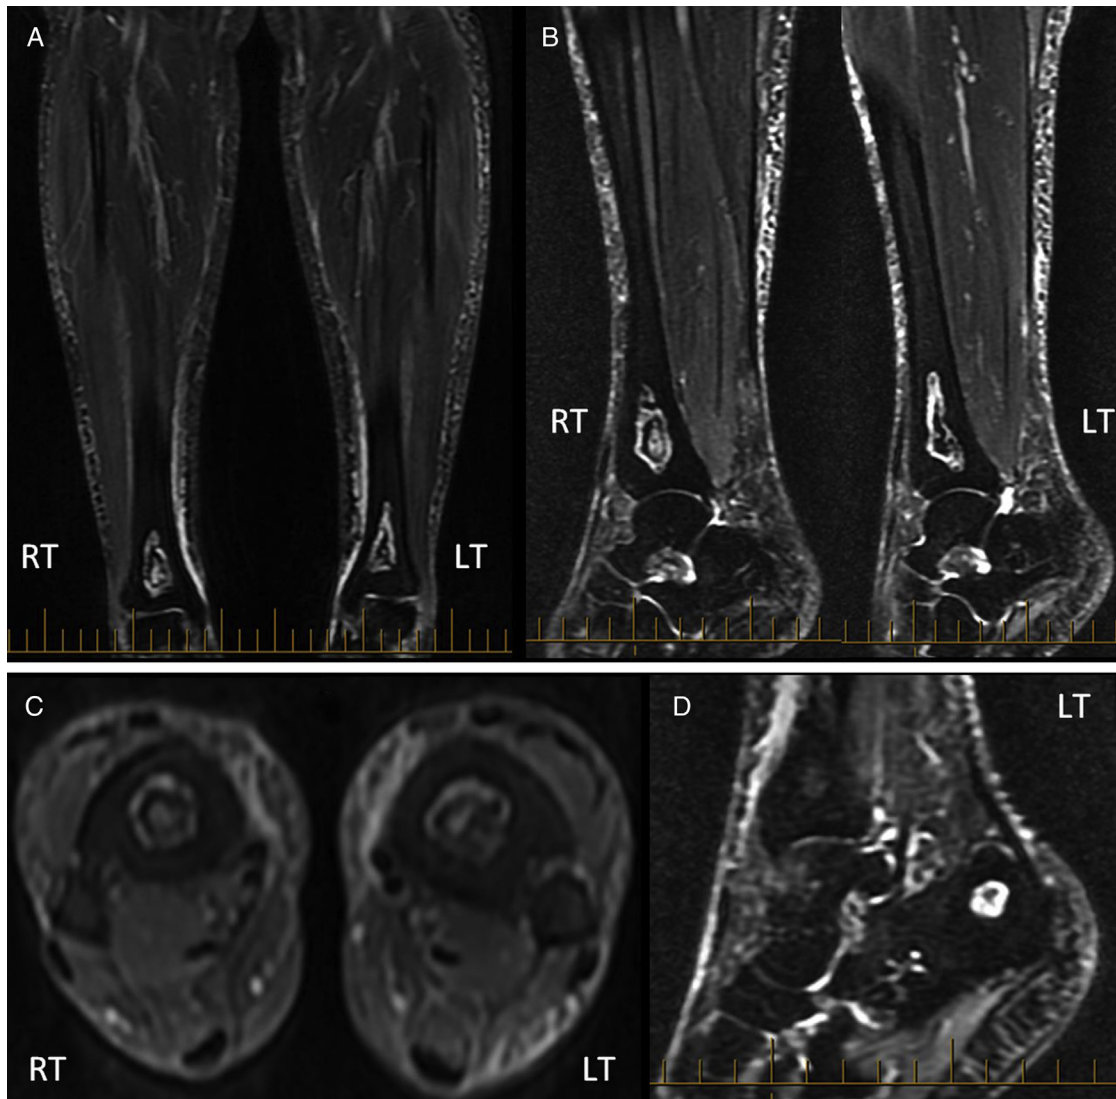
Magnetic resonance imaging study showing relatively symmetrical lesions of avascular necrosis in the coronal (A), sagittal (B), and transverse (C) slices of the bilateral diaphyseal–metaphyseal junctions of the tibias. (D) Note the osteonecrotic lesion in the tubercle of the left calcaneus. LT, left; RT, right.
